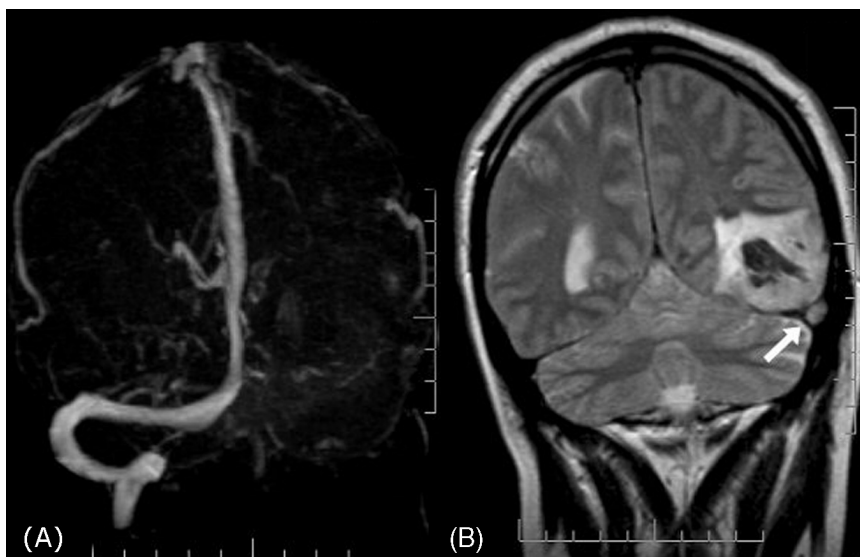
Transverse and sigmoid sinus thrombosis in TOF-MRA (A) and T2-weighted imaging (B). No flow signal within the region of the left sinus and direct visualization of the thrombus (arrow). Conventional sequences also reveal congestive edema and hemorrhage.
